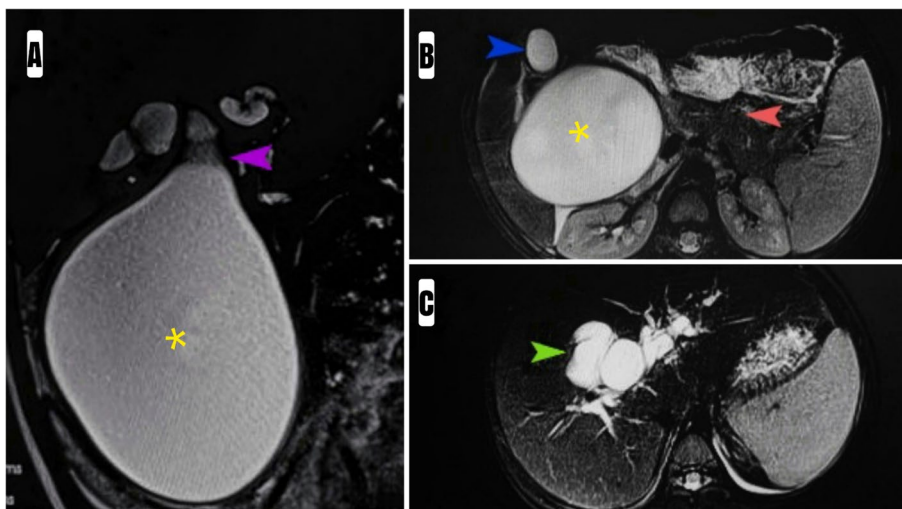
A–C: Preoperative MRCP (A and B) showing a cystically dilated common hepatic duct (purple arrowhead) and CBD (yellow asterisk). The main pancreatic duct (red arrowhead) and GB (blue arrowhead) are unremarkable. (C) Dilated bilobar central and peripheral intrahepatic biliary radicles (green arrowhead) are present. No T2-weighted hypointense filling defect was seen in the lumen
